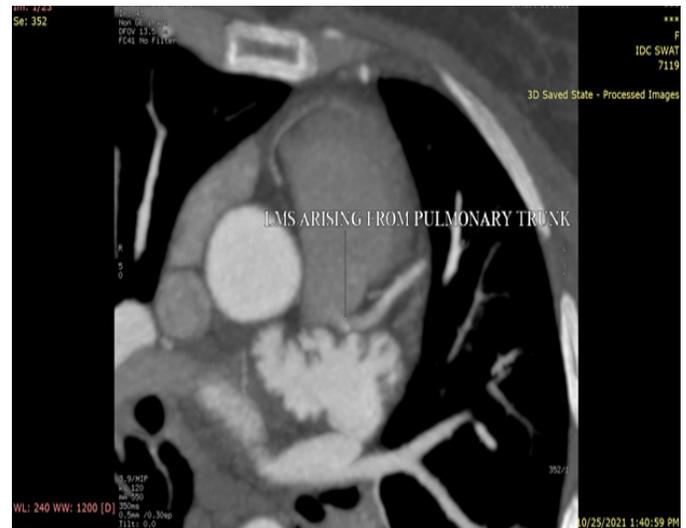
Axial CT coronary angiogram showing left main stem arising from pulmonary trunk, suggestive of pulmonary artery-derived anomalous left coronary artery (ALCAPA)
